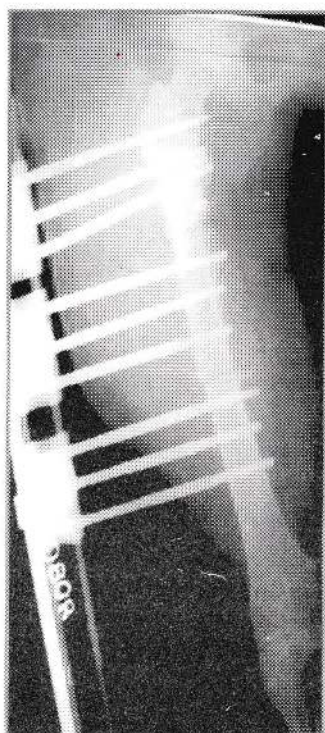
X-Rays of a patient
